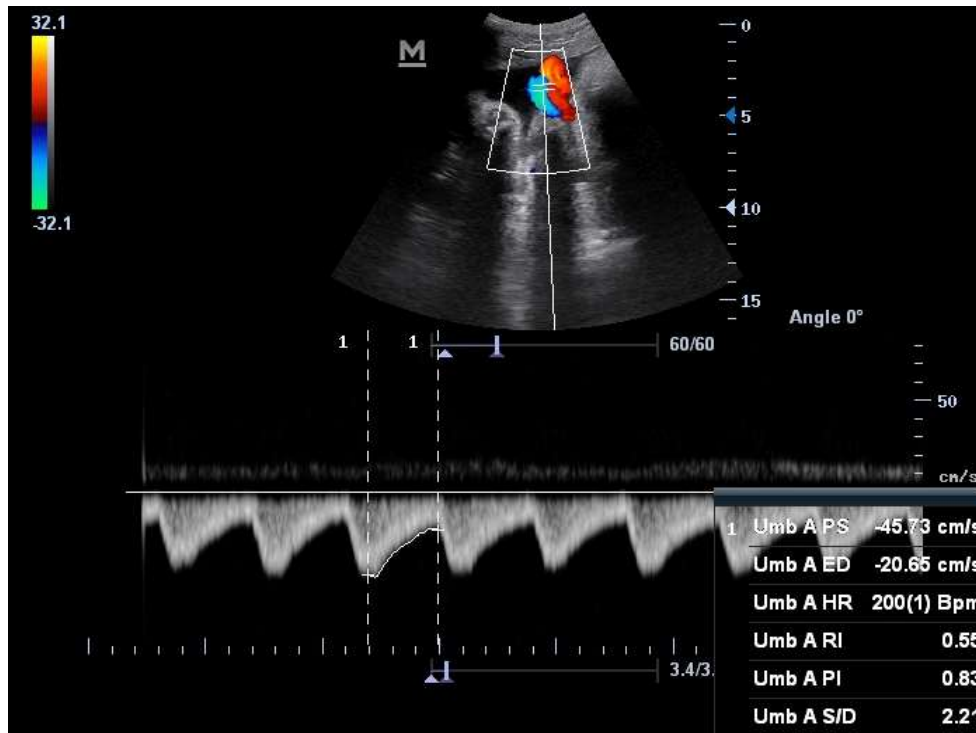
27 year old with preeclampsia at 36 weeks gestation. Normal UA and MCA Doppler
